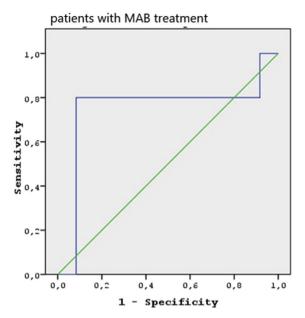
PSA level and PSMA PET positivity.
